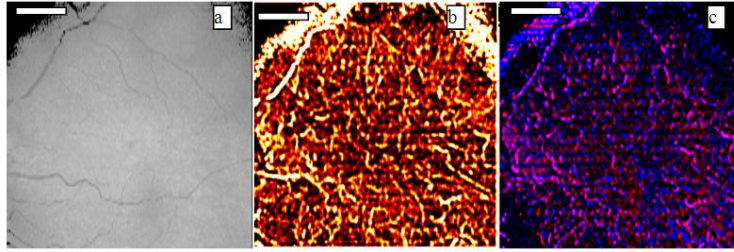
(a)OCT projection, (b) Doppler variance projection and (c) color Doppler projection images of choroidal vessels. Scale bar: 1mm.
